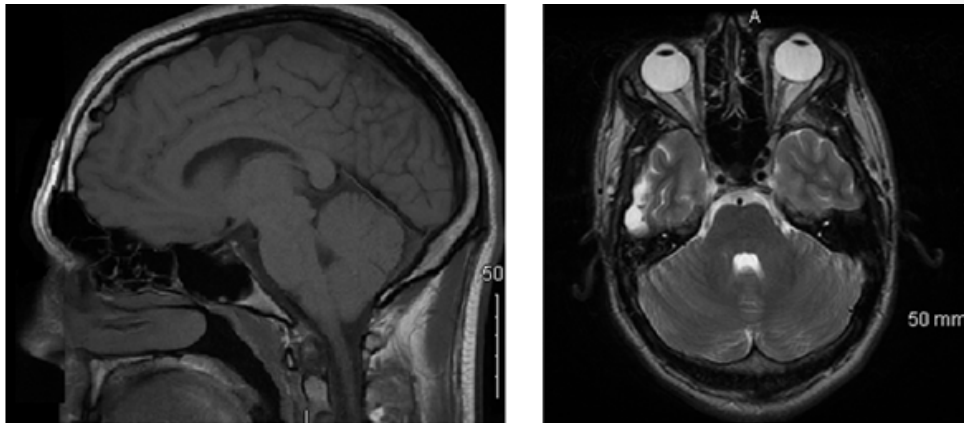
Magnetic resonance Image of head including Nasal Cavity [14]
